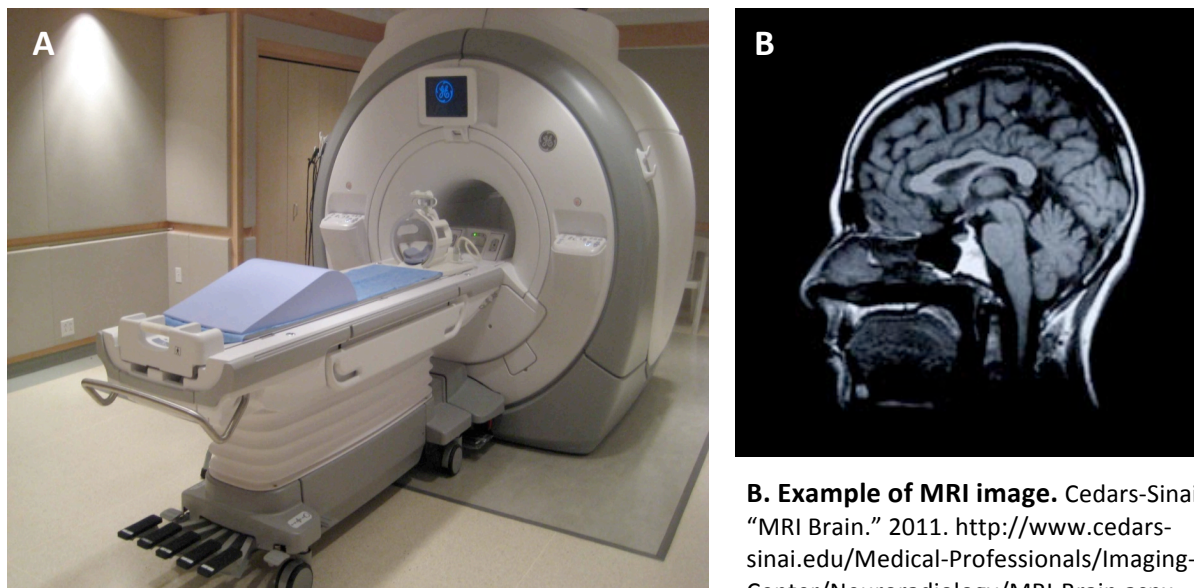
A. Example of MRI scanner. <http://www.usedct-scannersandmri.com/ge-ct-mri.html>
